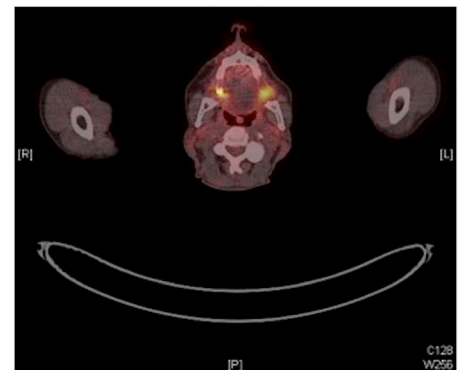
PET-CT revealing high uptake around the mandibular alveoli.
